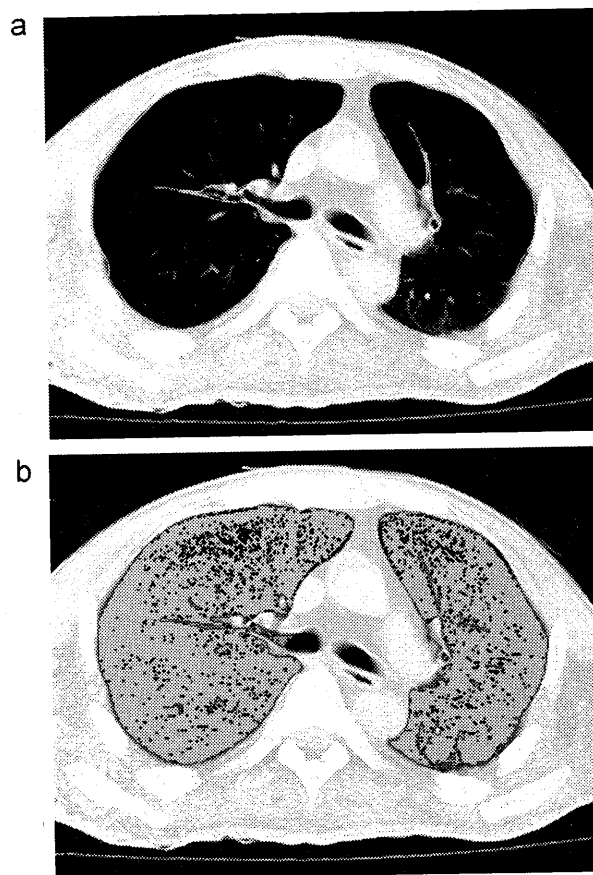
(a) A 69-year-old man, cause of death: fatal hypothermia, 48 h after inquest. Using Osirix semi-automated program, CC (a) and ALV (b) were measured on postmortem CT. Then, %ALV was calculated employing the results obtained. (b) A 69-year-old man; cause of death, fatal hypothermia, 48 h after inquest Using Osirix semi-automated program, CC (a) and ALV (b) were measured on postmortem CT. Then, %ALV was calculated employing the results obtained. CC, 2183.8 mL; ALV, 1793.9 mL; %ALV, 82.1%; CC, chest cavity; ALV, aerated lung volume; %ALV, percent aerated lung volume.
